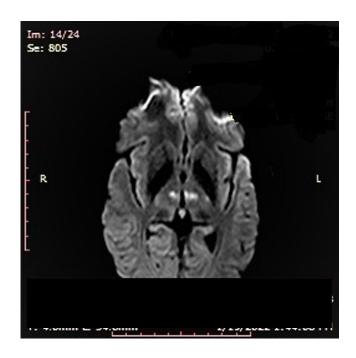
MRI brain showing diffusion restriction in bilateral paramedian thalami and midbrain.
